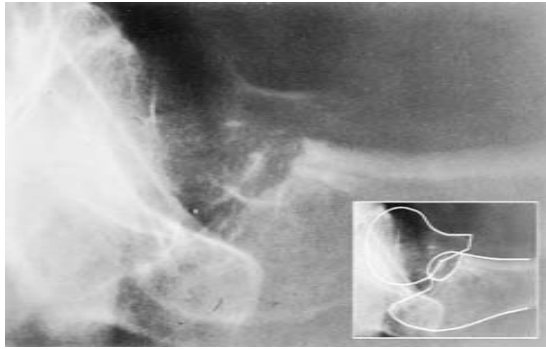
Intraoperative lateral radiograph of a posteriorly sagged caudal fragment.
